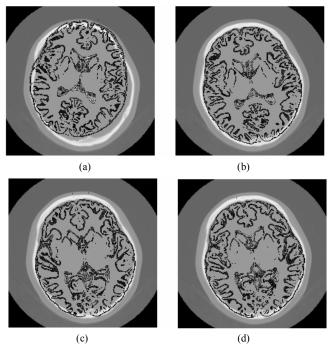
Demonstration of a typical result of clinical CT-MRI datasets registration. The 2D slice through 3D volume of MRI contour line overlays CT before registration (a), after registered by the NVI method (b), after registered by $MI_M(c)$, and after registered by NMI (d).
